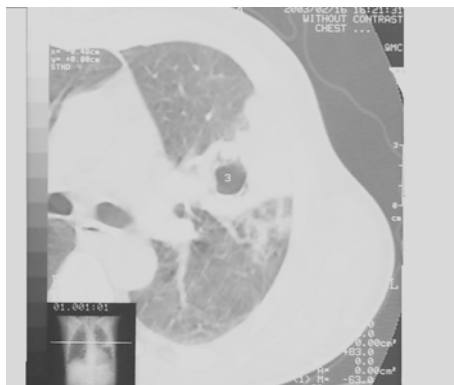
CT scan of patient with mucormycosis
